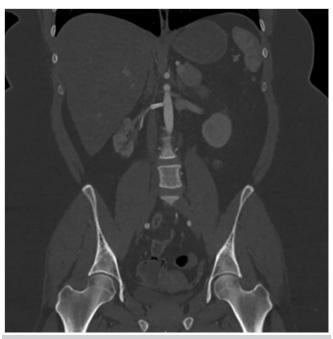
Computed tomography angiography at 5 months after intervention demonstrating renal stent patency and renal arterial perfusion with some small regions of chronic infarcts.
